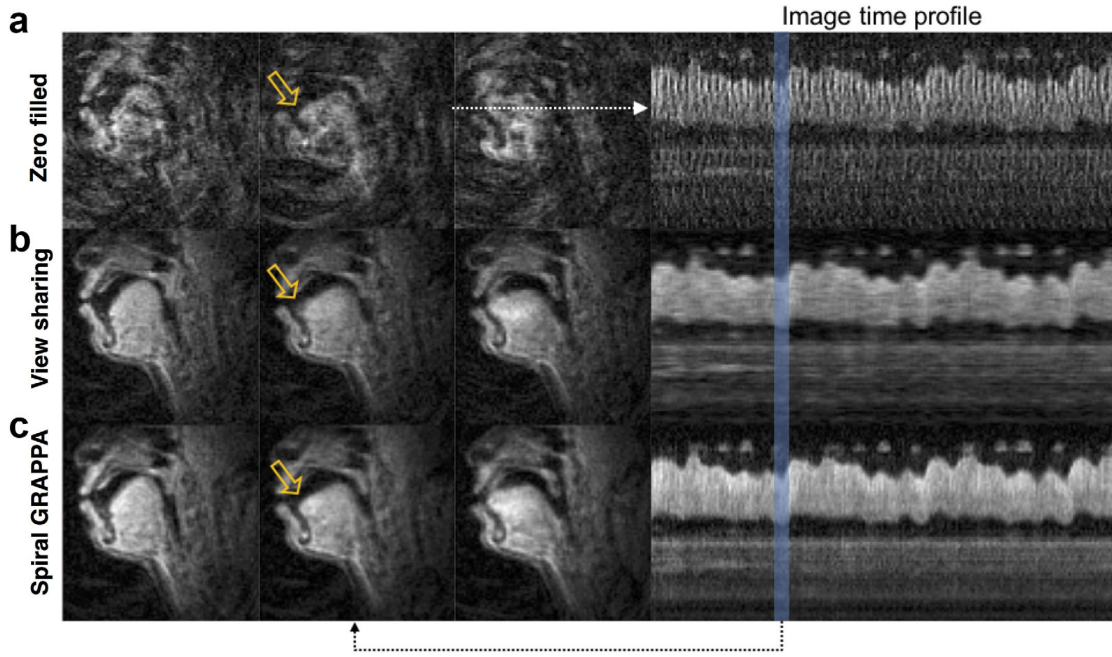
RT-MRI of fluent speech with (a) zero-filled reconstruction at  $R=4.3$  (3 TR, 18 ms); (b) view-sharing reconstruction (step size: 3 TR; frame rate: 55 fps; native time resolution = 78 ms); (c) through-time GRAPPA reconstruction at  $R=4.3$  (3 TR, 18 ms). The subject produced the phrase “one-two-three-four-five” at a rapid pace. The first three columns show a sequence of spatial frames corresponding to the timing of the tongue tip hitting the palate, and the last column shows the image time profiles at the cross-section marked by the white dotted arrow. Zero-filled-based images show considerable undersampling artifacts. View sharing captured slow dynamic movements well, but blurred rapid movements. In contrast, through-time spiral GRAPPA provided improved temporal fidelity of rapidly moving articulators. For instance, subtle tongue tip shaping is seen to be captured with spiral GRAPPA while blurred with view sharing (see solid yellow arrows).
